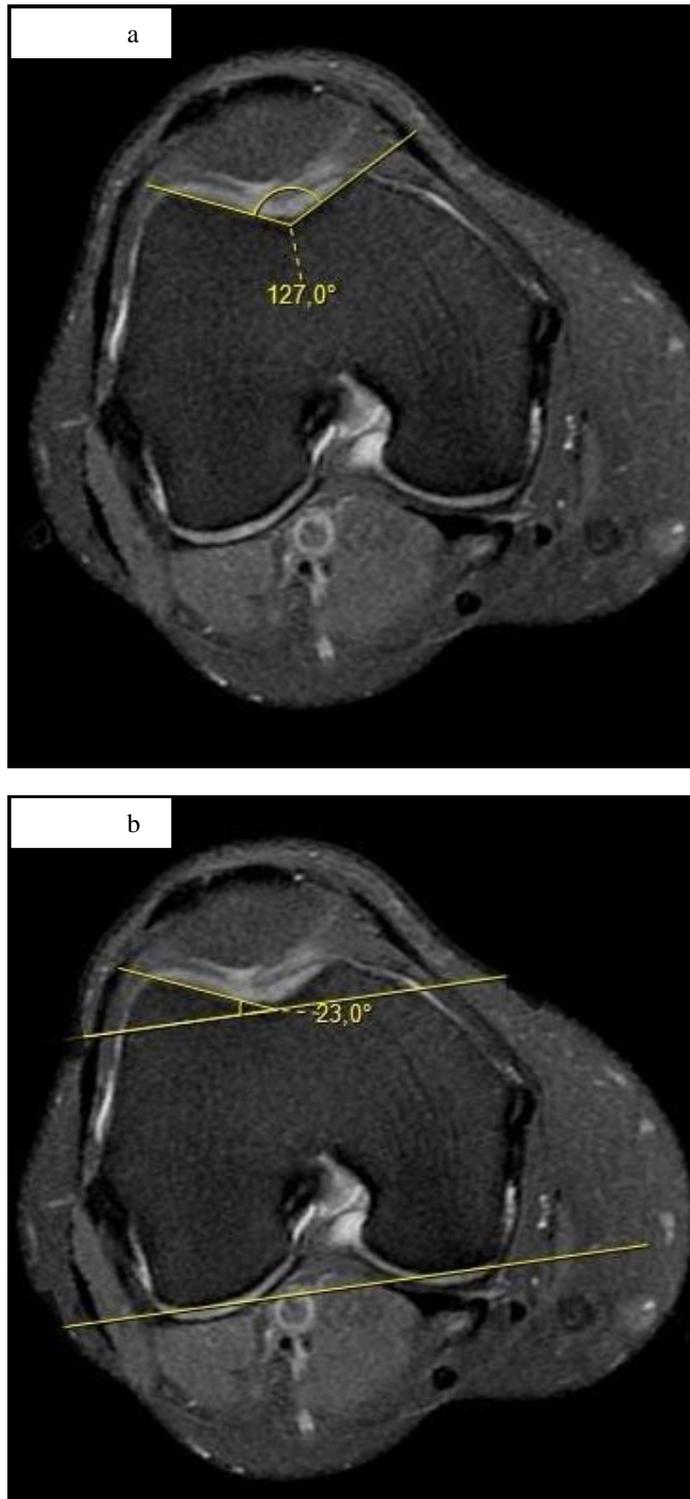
(a-d). Axial fat-suppressed PDW-MR images of the knee showing SA (a), LTI (b), MTI (c), and FA (d).
